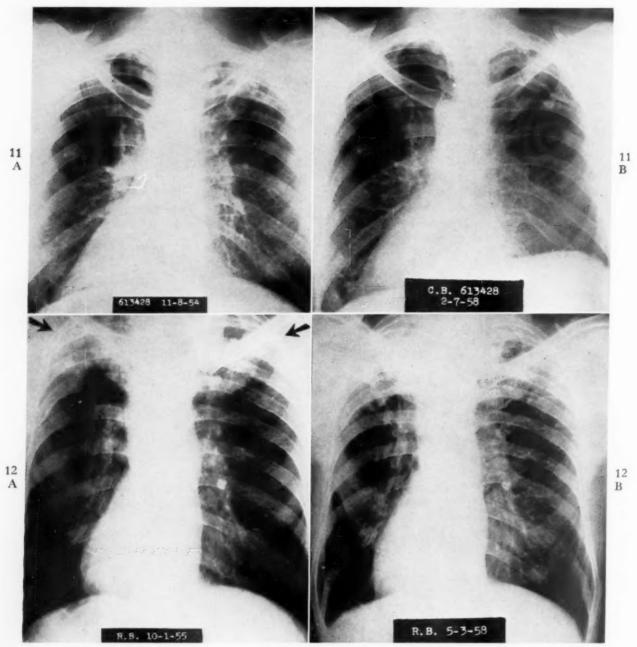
Case vii. Chest roentgenograms. A, before right upper lobectomy showing infiltrative lesion with multiple small cavities. B, three years and three months postoperatively. There is no recurrence of the lesion.
